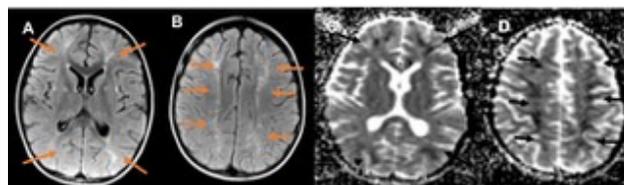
Cranial MRI of a 6-year old male intoxicated from stove shows bilateral asymmetrical hyperintensities in the anterior and posterior border zones on T2-weighted images (A-B) (red arrows) corresponding to areas of diffusion restriction on ADC images (C-D) (black arrows), consistent with acute border zone infarctions
